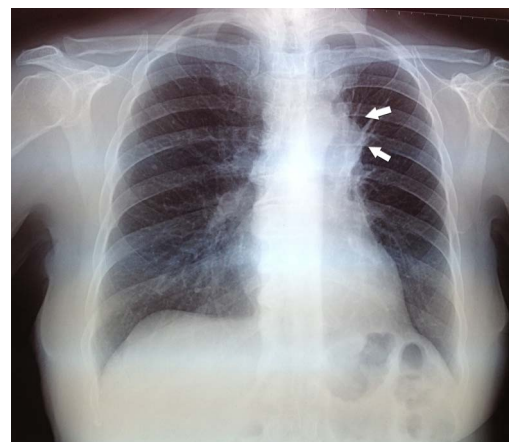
Chest radiograph (posteroanterior view) showing a semicircular opacity in the left upper thorax with the base located in the mediastinum (white arrows show the lateral edge).
